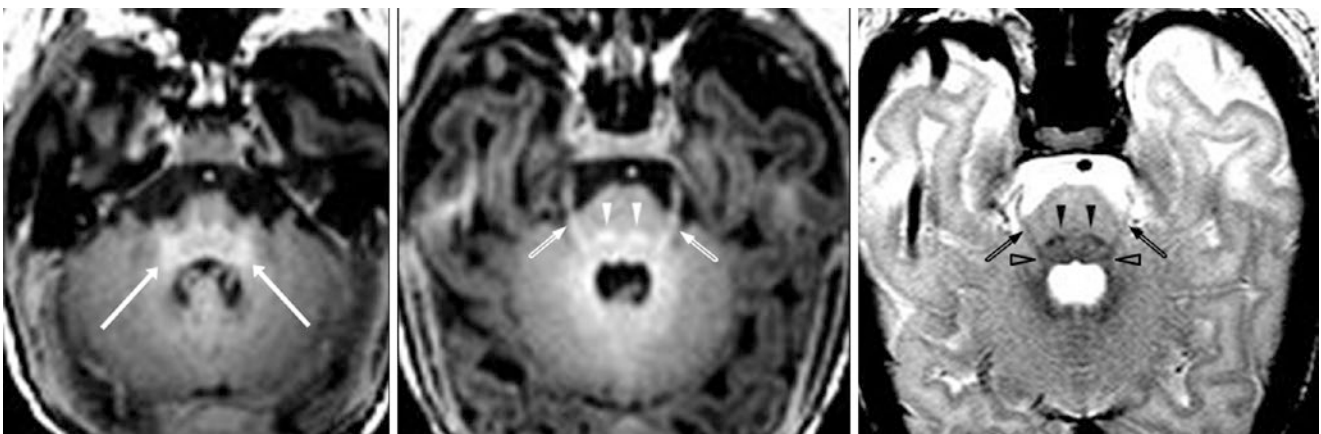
A 6-day-old term neonate had a normal 3T MRI with GE T1WI (*left and middle*) and SE T2WI (*right*). Note the ICP (*long arrows*), LL (*open arrowheads*), ML (*arrowheads*), and CNV (*beveled arrows*). The fascicles of CNV can be followed anteriorly as the nerves into the cistern on both sides
